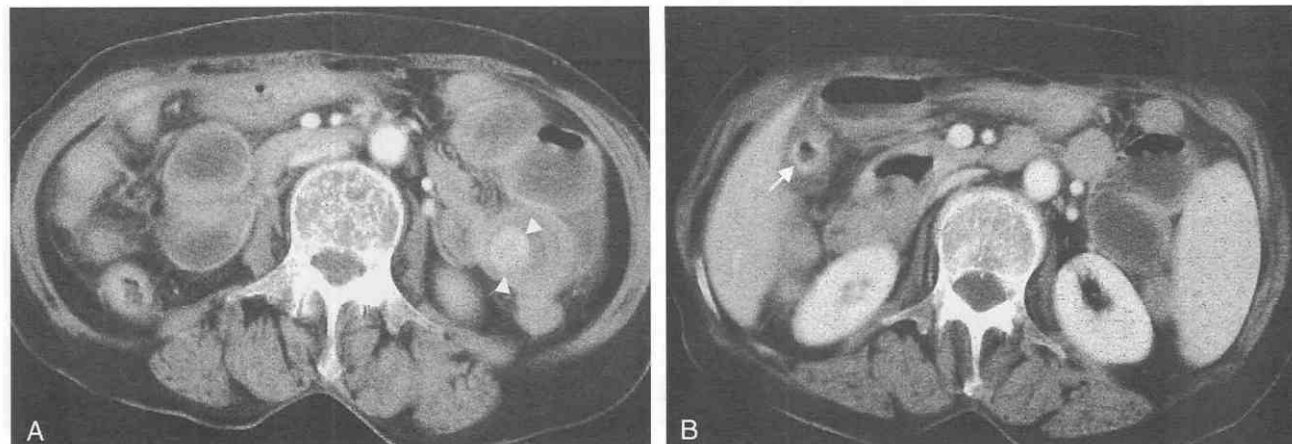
Gallstone ileus. *A*, CT scan shows a high-attenuated stone (arrowheads) obstructing the small-bowel loop. *B*, CT scan at higher level shows contracted and gas-filled gallbladder (arrow) with diffuse pericholecystic infiltration.
